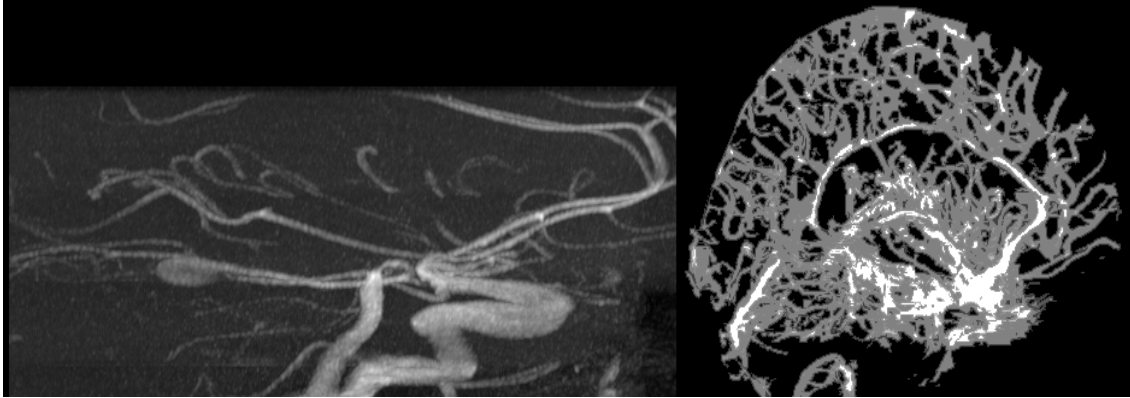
Arterial imaging modalities. (Left) Maximum intensity projection (MIP) image of TOF-MRA image displays flowing arterial blood. (Right) Both veins and arteries appear in the computed tomography angiography (CTA) segmented blood vessel image making arteries difficult to distinguish.
